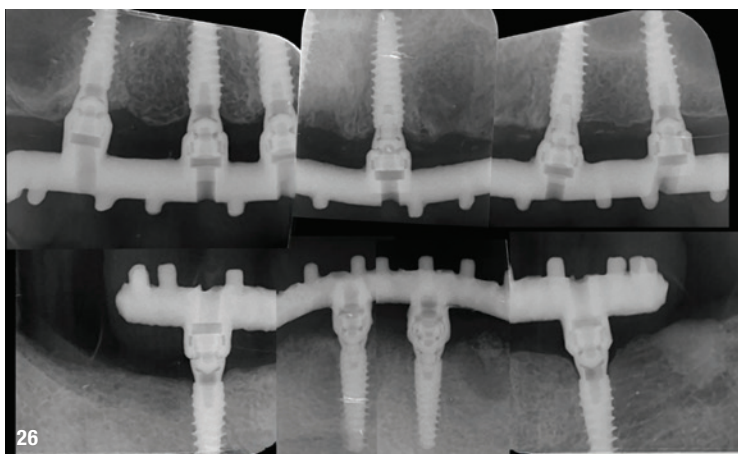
Control radiograph.
